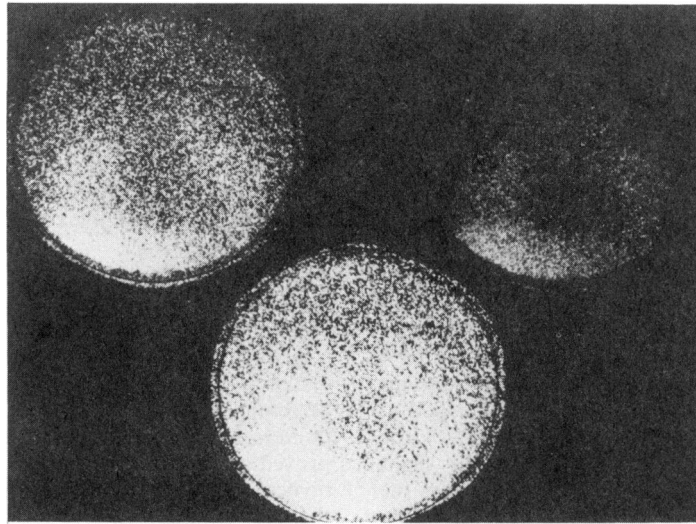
Precordial scintigram obtained in a normal man 227–237 min after injection of 20 µCi/kg of [¹³¹I]-RIBA. In the recording system used here, the camera automatically displayed a trio of simultaneous images on all occasions; the images in each trio differed in intensity. In this man pulmonary densities are clearly seen on each side of the heart. The heart itself shows little density. The upper portion of the liver is also seen at the bottom.
